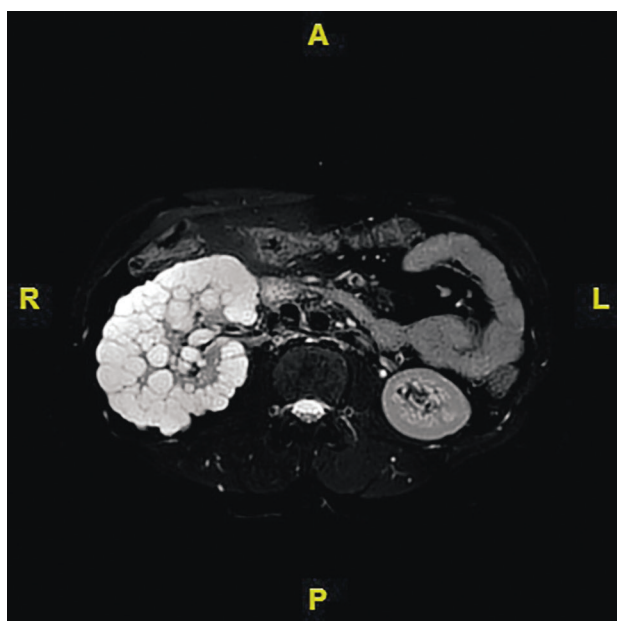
Coronal T2-weighted MR images show unilateral multiple cysts in the right kidney. Note that majority of the cysts are located peripherally consistent with lymphangiomas.
